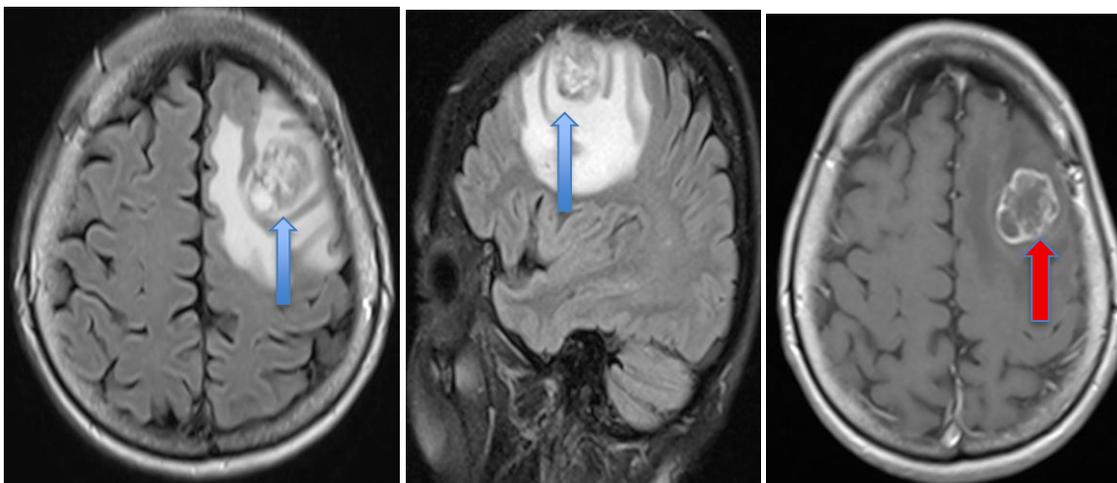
Brain MRI Left Frontal lesion(blue arrow) with enhancement of contrast (red arrow)
